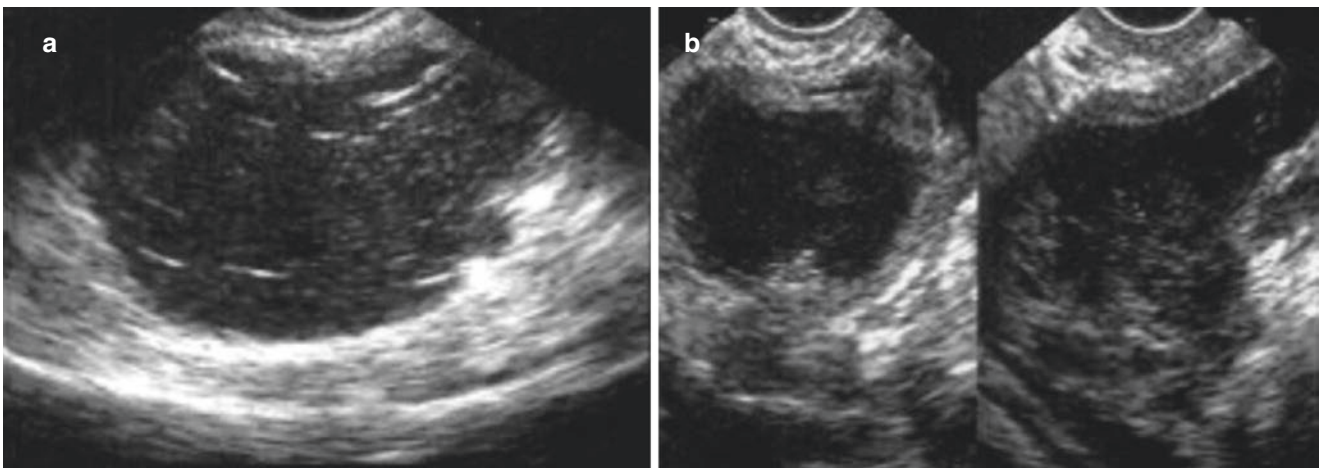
Pelvic abscess. (a) A 34-year-old patient represented lower abdominal pain half a year after an operation because of pelvic abscess. The ultrasonography shows a hypoechoic mass located in the posterior and right of the uterus, 8.0 cm in diameter, with tiny and short linear
